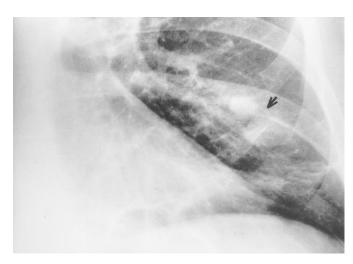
Magnified view of the left lower lung field from a plain chest radiograph showing a single, bilobed PAVM with smooth borders (arrow). There is an area of infiltrate from a recent episode of adult respiratory distress syndrome that lies inferior and lateral to the PAVM.
